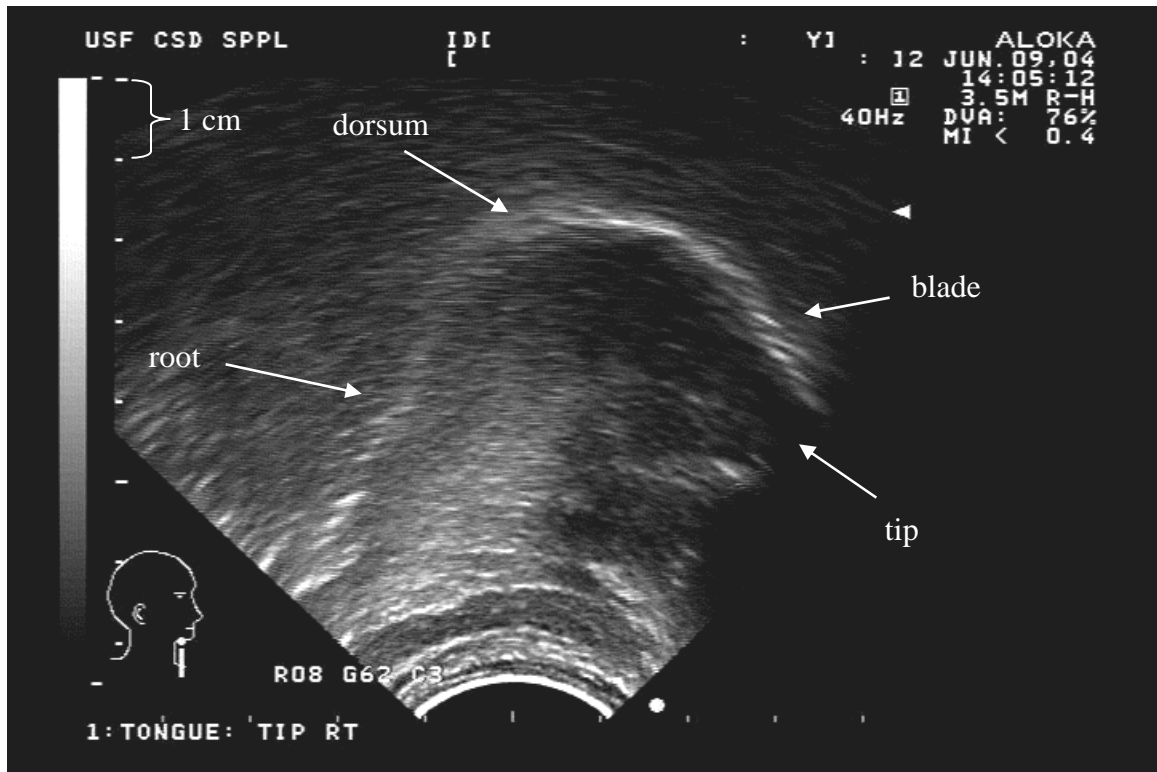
Sagittal view of the tongue body with ultrasound; tongue tip to the right
